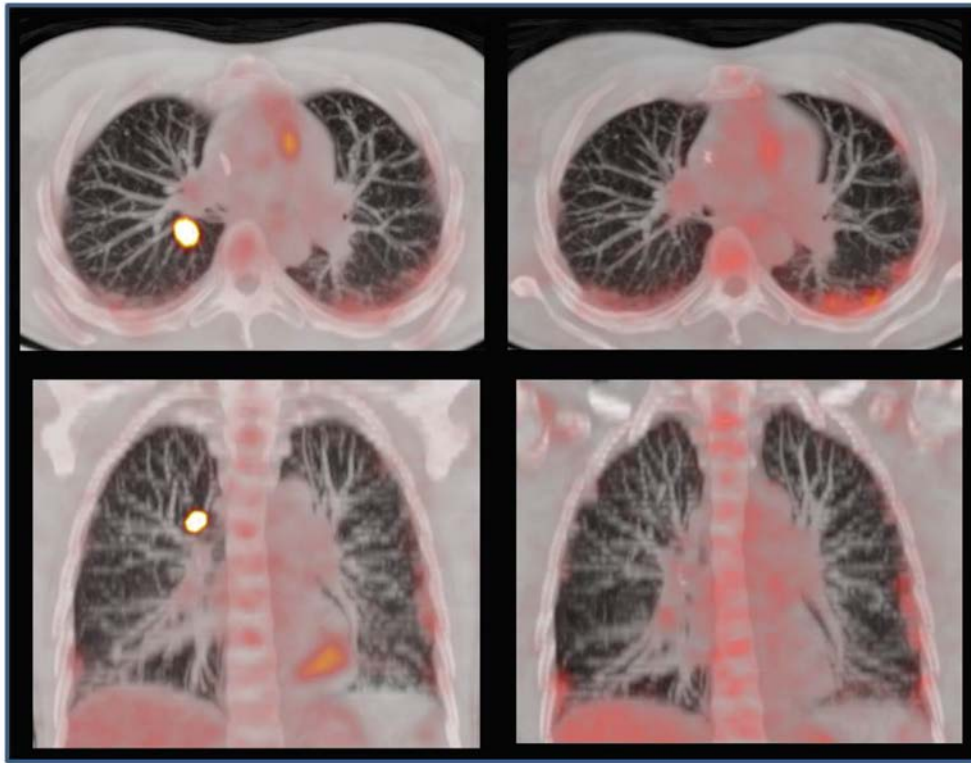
Left: FDG-PET/CT study demonstrating focal lung uptake consistent with suspected recurrent disease. Right: follow-up FDG-PET/CT study two days later demonstrates resolution of apparent lung lesion. The original focal uptake was presumably caused by a microembolism.
